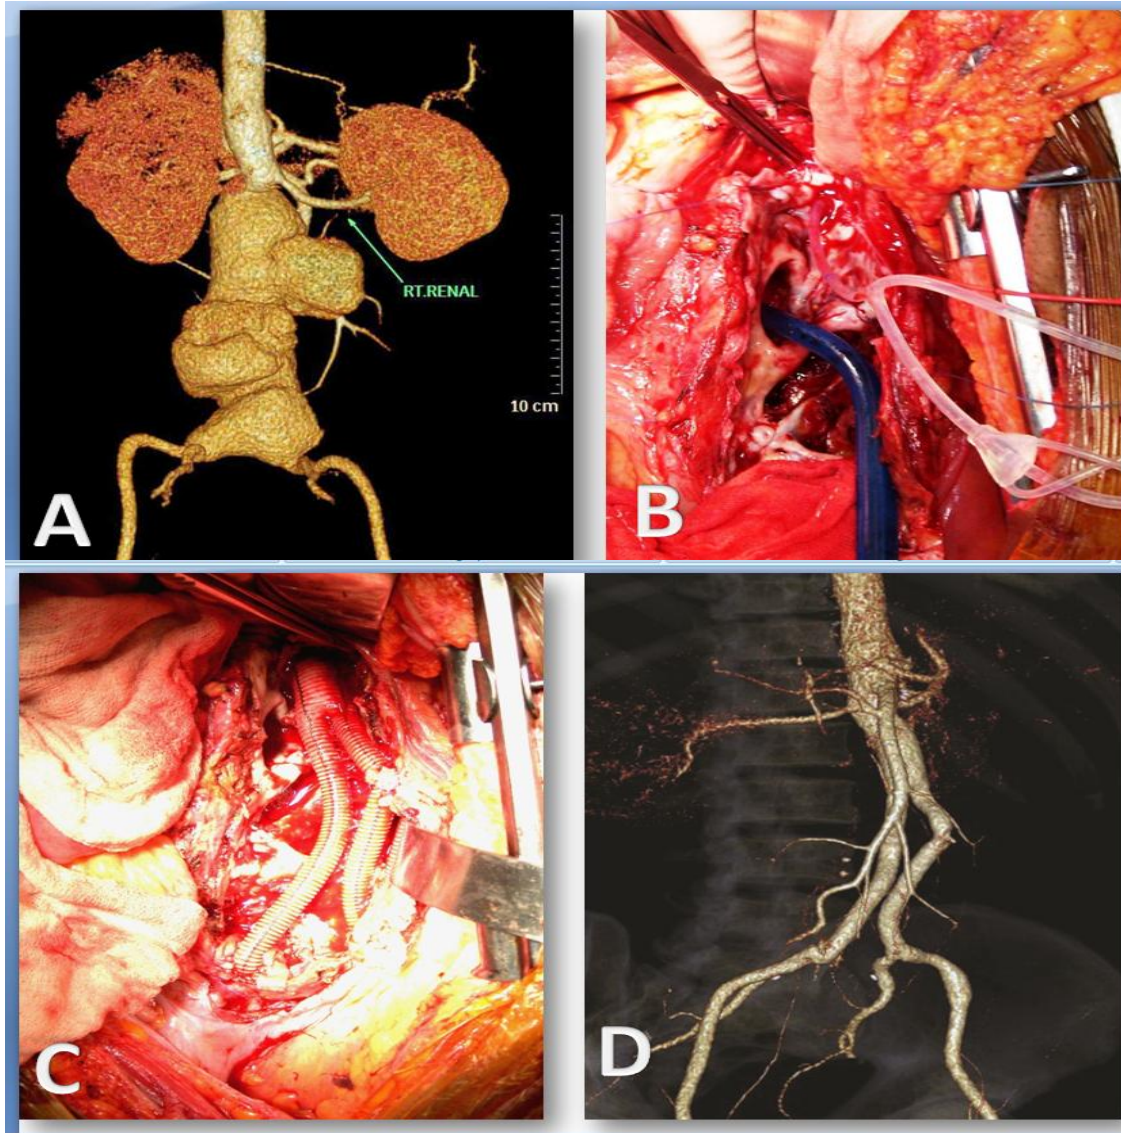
Juxtarenal AAA. Preoperative CT VRT picture of the juxta renal AAA (A), intraoperative picture showing selective renal perfusion using a Pruitt-Inahara shunt (B), Intraoperative picture after graft implantation (C), CT VRT picture 6 months after the procedure (D).
